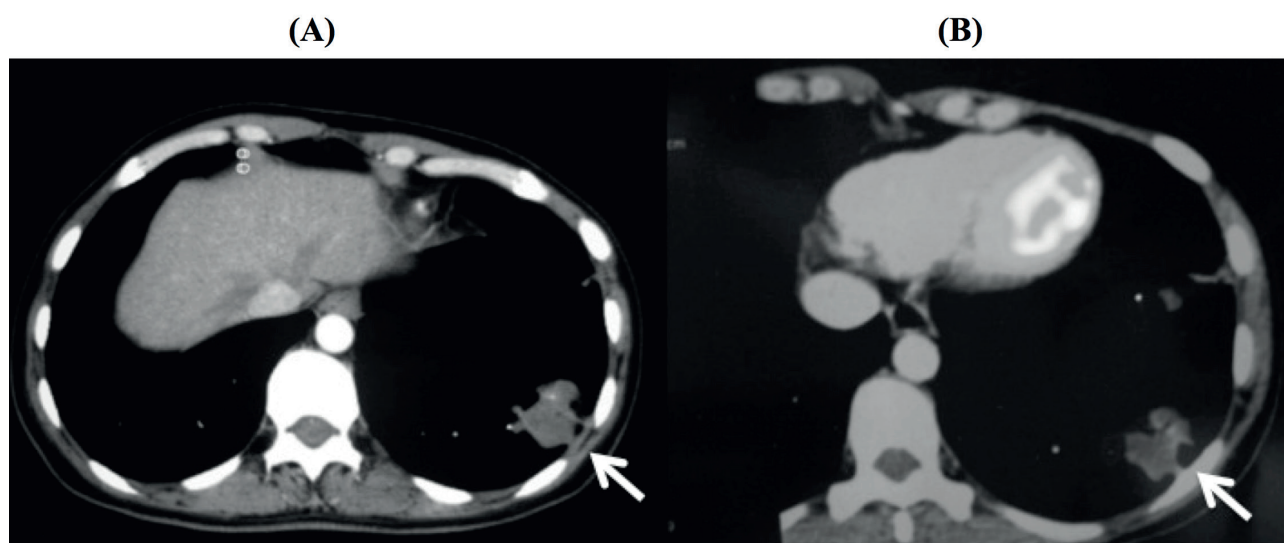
CT (A) and PET (B) scans. PET scan shows SUVmax 5.4 suggestive of malignancy. The lesion is shown by arrows. The final diagnosis was tuberculosis.
